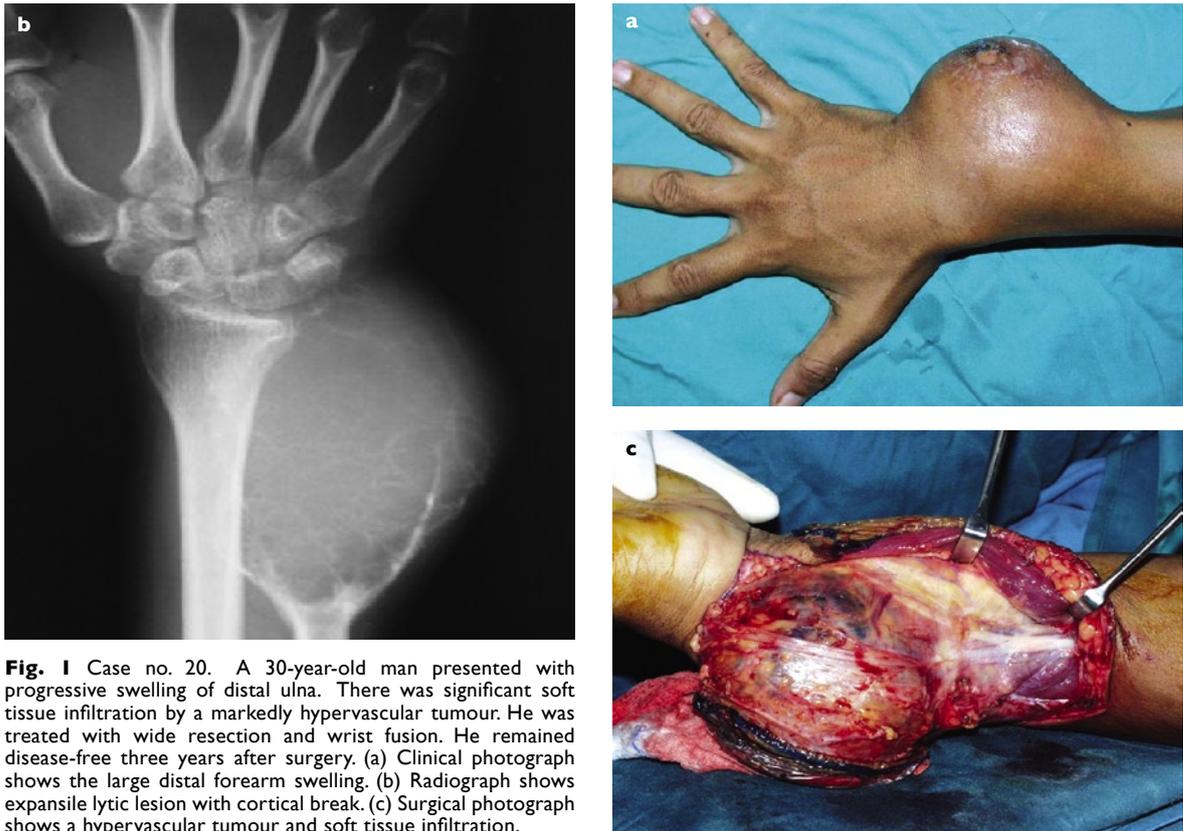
Case no. 20. A 30-year-old man presented with progressive swelling of distal ulna. There was significant soft tissue infiltration by a markedly hypervascular tumour. He was treated with wide resection and wrist fusion. He remained disease-free three years after surgery. (a) Clinical photograph shows the large distal forearm swelling. (b) Radiograph shows expansile lytic lesion with cortical break. (c) Surgical photograph shows a hypervascular tumour and soft tissue infiltration.
